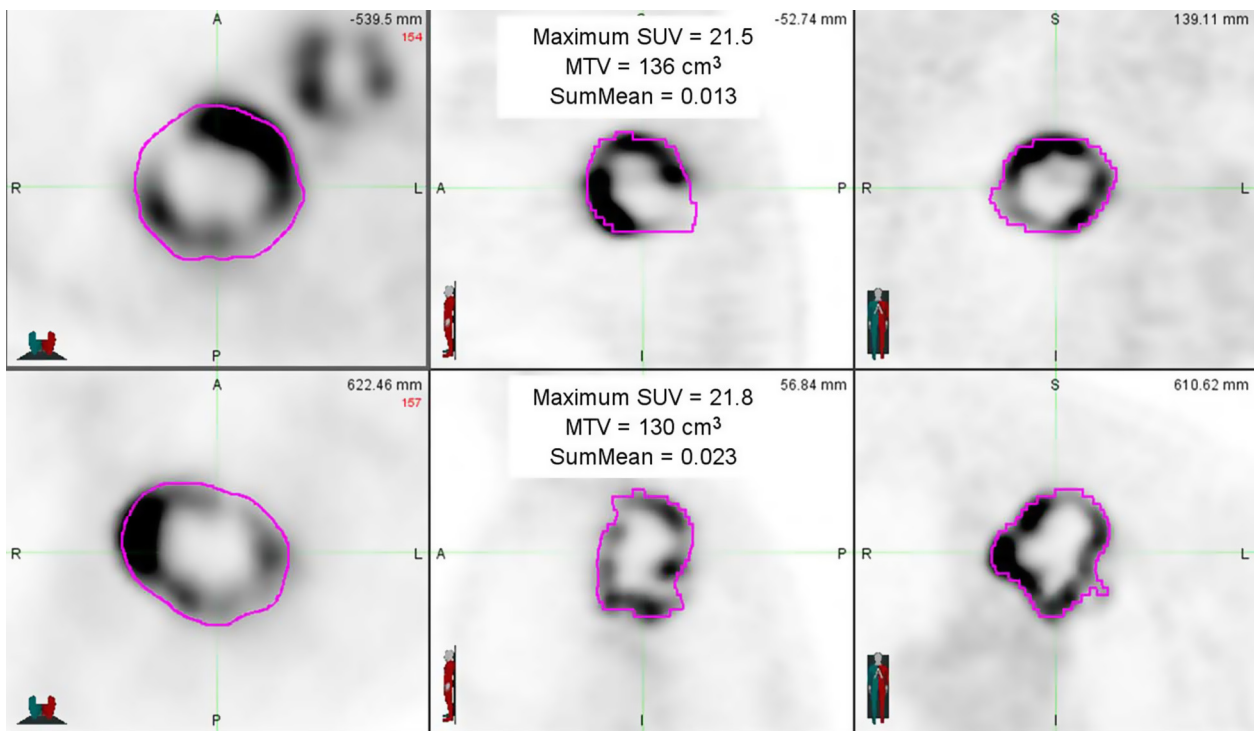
PET images from two sample patients whose tumors had similar MTV and SUVmax and similar appearances, but had disparate SumMean values. Both tumors were scored as markedly heterogeneous based on visual examination. Survival time for the patient in the upper panel was 15.5 months, compared to 47.8 months for the patient in the lower panel (reproduced with permission from [43]).
